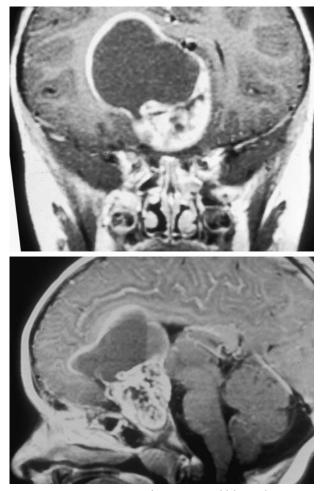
MR images of an 11-year-old boy who presented with headache and visual deficit bilaterally. The coronal MRI (*top*) is a T1-weighted, contrast-enhanced view in which the cyst wall and the inferior solid portion of the tumor reveal strong signal enhancement. The midsagittal, T1-weighted view (*bottom*) shows the marked enlargement of the sella by the tumor; optic chiasm cannot be identified.
